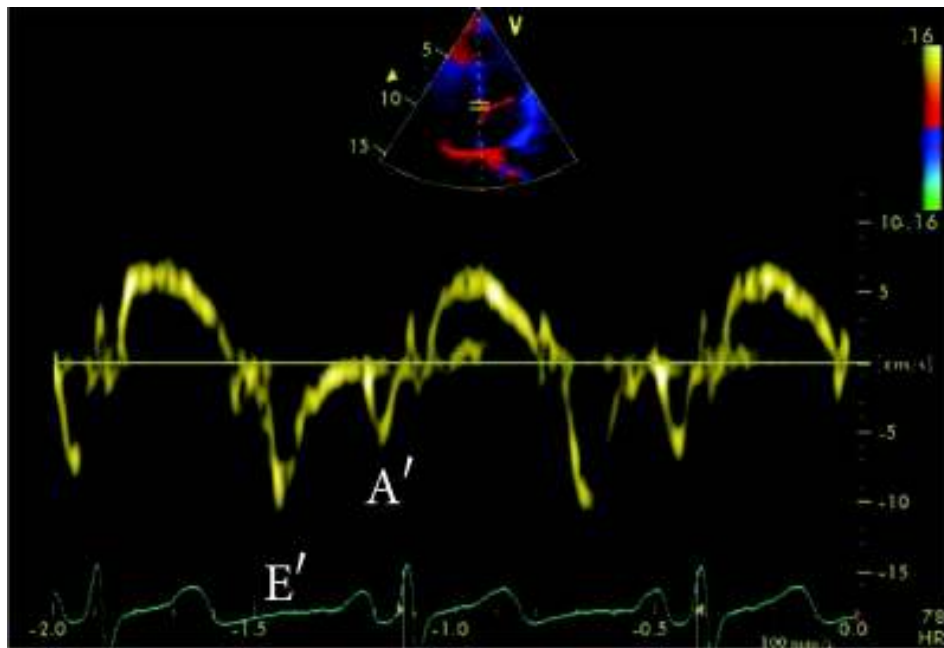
Tissue Doppler imaging of medial annulus. ⁽¹⁵⁾
